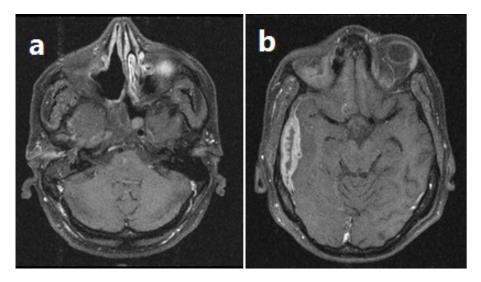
Axial contrast Magnetic Resonance Imaging (MRI)
